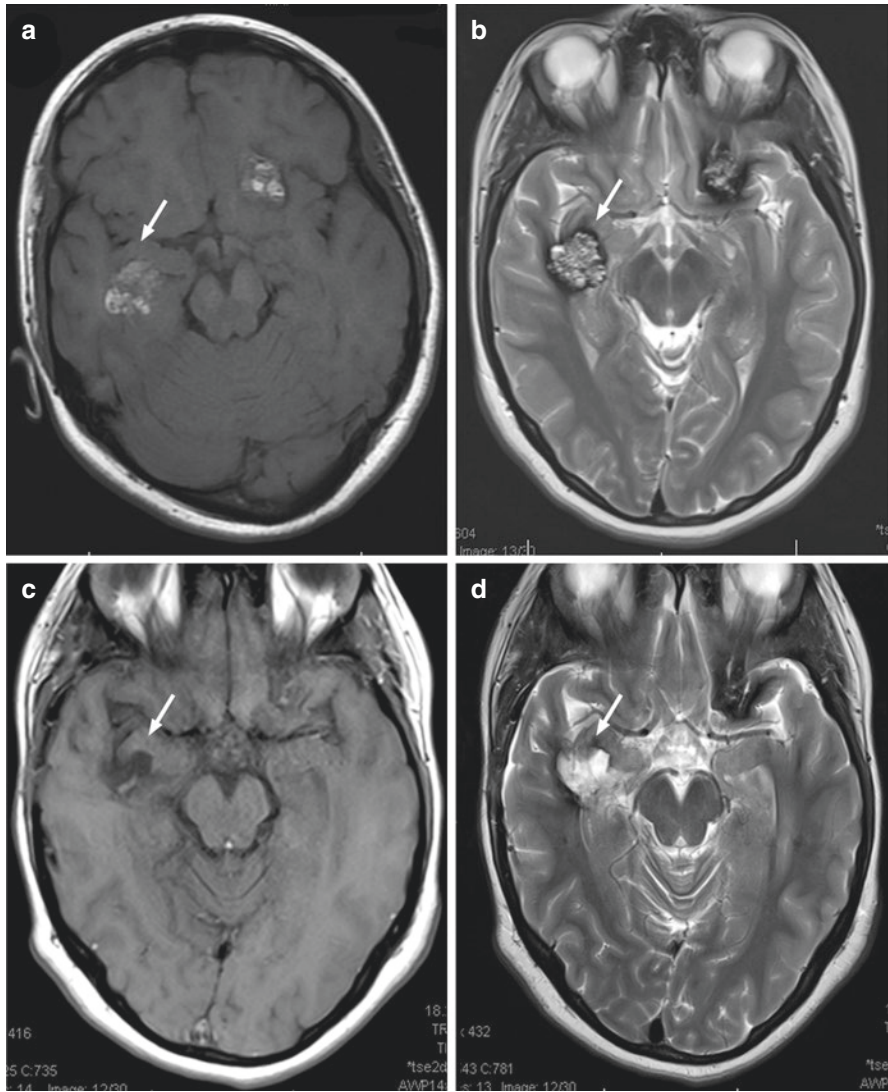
Case 2—Resection of a symptomatic right temporal CM. Preoperative axial (a) T1-weighted and (b) T2-weighted MR images demonstrate right subfrontal and left temporal (arrow) CMs. Postoperative axial (c) T1-weighted and (d) T2-weighted MR images are shown after resection of the right temporal CM (arrow)
